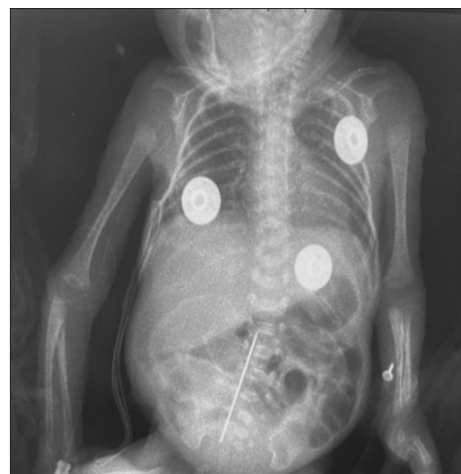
Chest X-ray of the neonate showing intestinal obstruction and perforation
